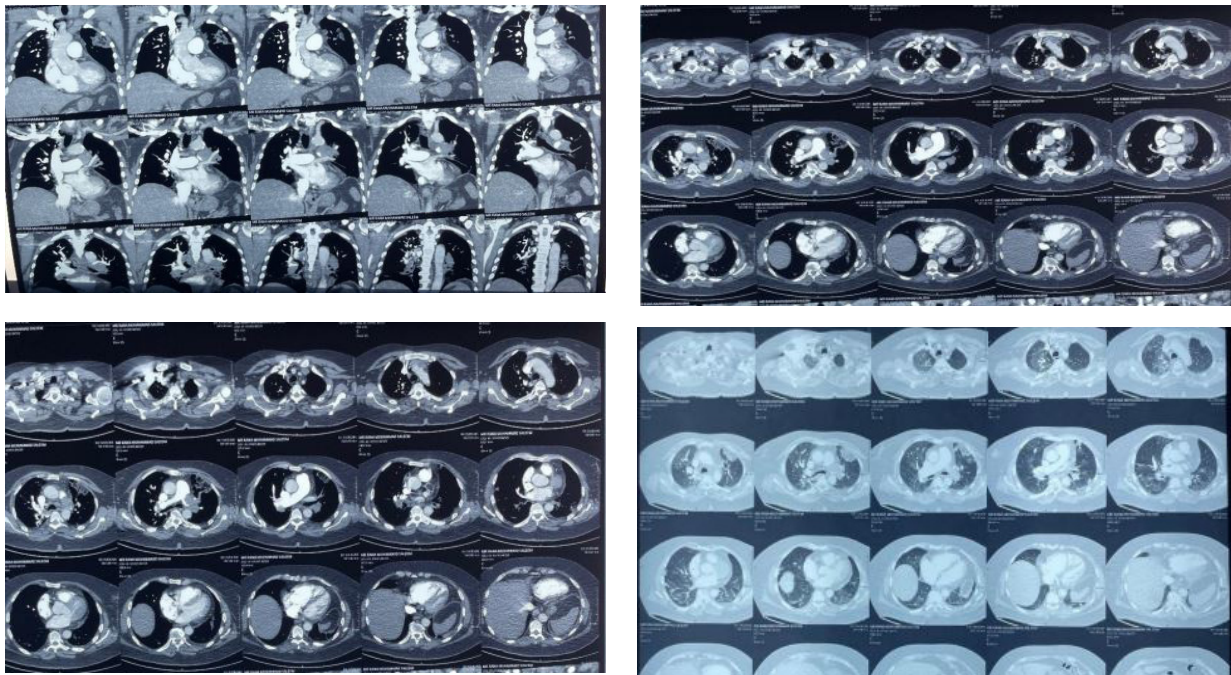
CT pulomnary angiogram which showing bilateral extensive pulmonary embolism involving almost entire left main pulmonary artery with extention into distal right pulmonary artery.
